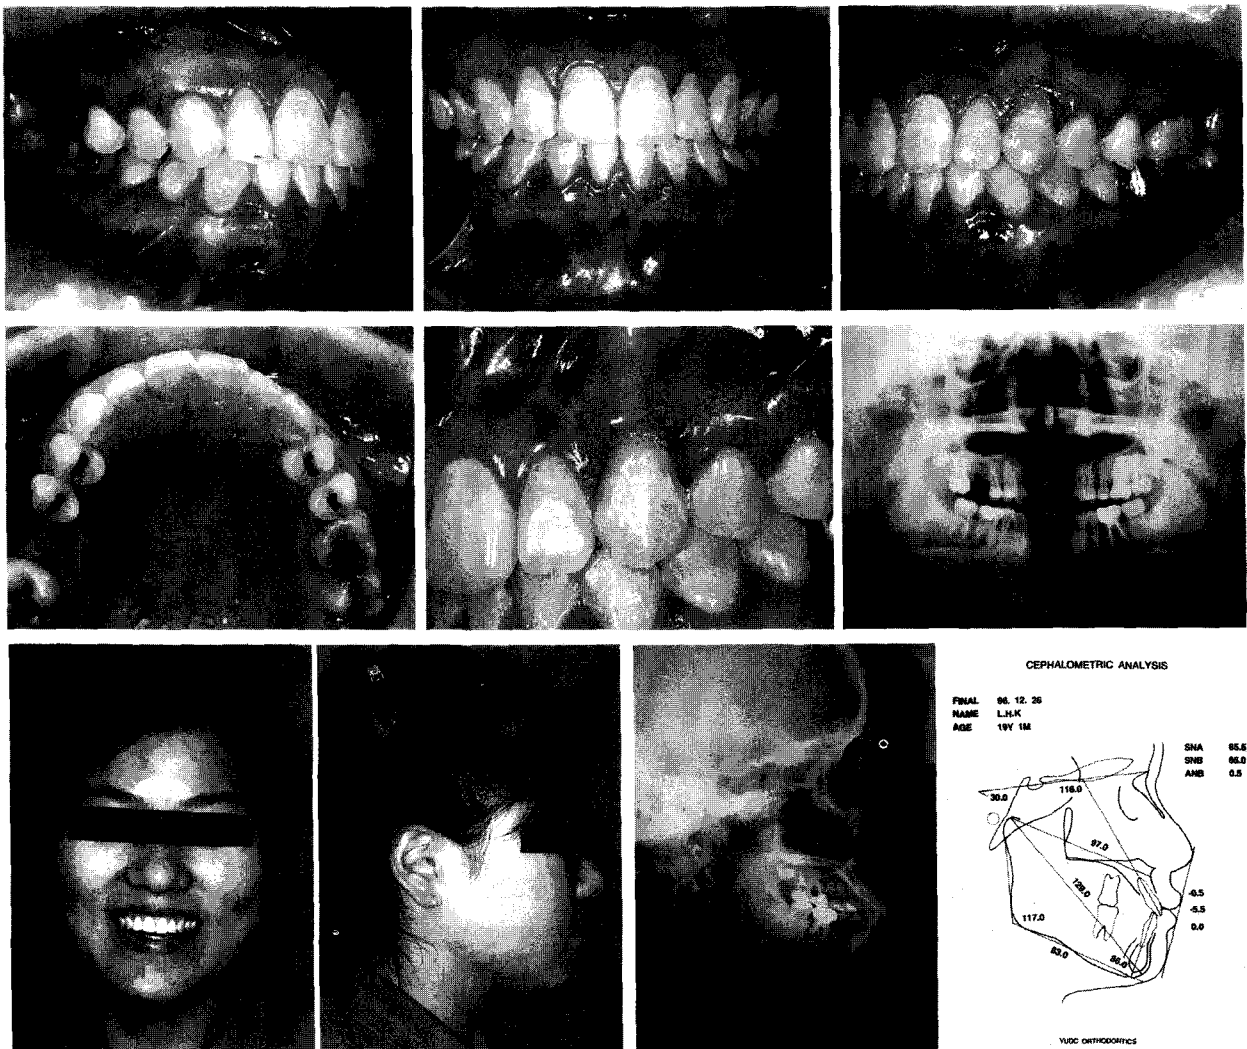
Case 2. Final intraoral photos, facial photos, lateral cephalogram, orthopantomogram, and cephalometric tracing
